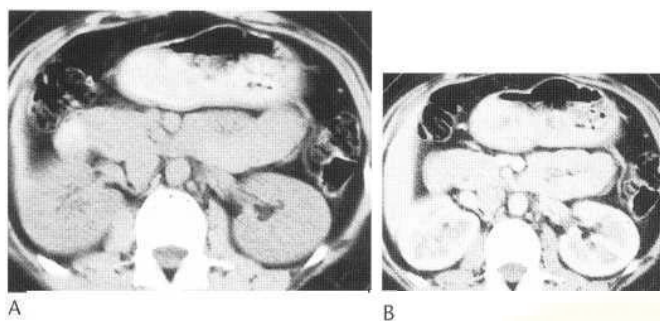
Transverse CT through the midpart of the kidneys. Prior to contrast the kidneys are of intermediate density (A), similar to liver, spleen and blood vessels. During the nephrogram phase the cortex is seen to enhance earlier than the medullary pyramids (B).
